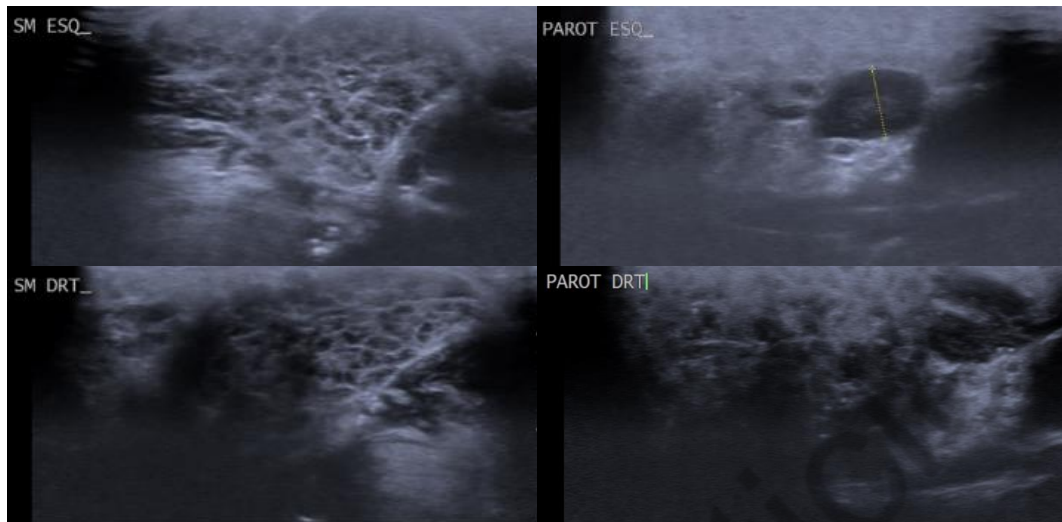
Parotid (PAROT) and submandibular (SM) gland ultrasound frames showing heterogenous micronodular enlargement.
